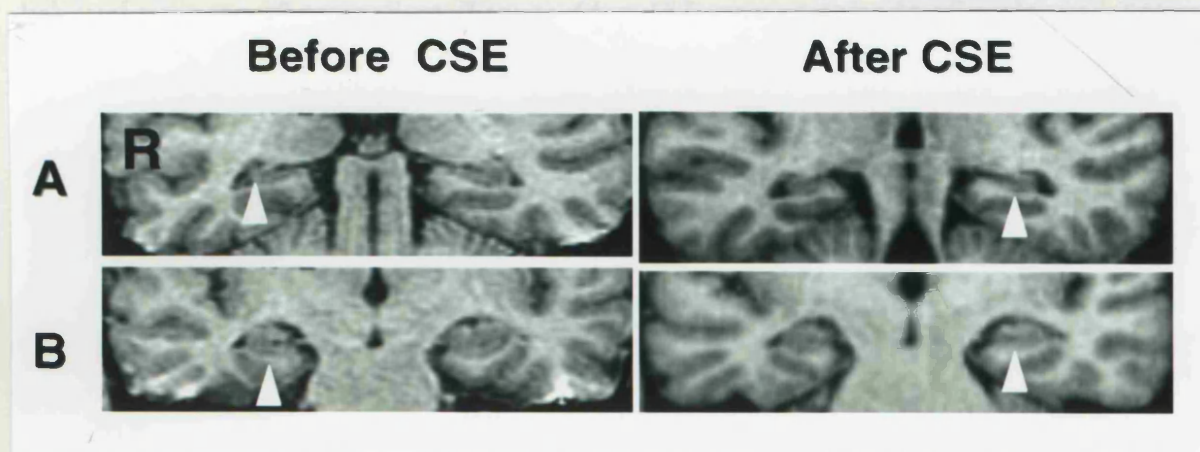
Progression from unilateral to bilateral HS. The patient was a 46 year old right handed man whose birth and early development were normal. The onset of habitual epilepsy was at the age of 4 years. There was no history of meningitis or FCs. The first seizure was an episode of CSE with left sided predominance, left sided Todd's paresis and right sided EEG focus. At the age of 12, he had 4 SGS with left sided predominance and no recovery of consciousness between seizures. He had a left Todd's paresis which resolved over one day. He had on average 4 SGS a year and was seizure free for 9 years from the age of 28 to 37 years. At the age of 35, he developed CPS with no aura, characterized by a vocalization, followed by staring, smacking movements of the mouth and swallowing, and dystonic posturing of the left arm with occasional SGS. The seizures continued at a frequency of 2 to 3 per year. At the age of 46 years, MRI of the brain (GE Signa 1.5 T, SPGR volume acquisition) showed right hippocampal atrophy without signal abnormality (white arrows in "before CSE"). Right HCV was 2877 mm^3 which was 5 SD below mean control values ($5180 \pm 416 \text{ mm}^3$) and the left HCV was 4095 mm^3 , which was 2 SD below mean control values. The HCVR (R/L) was 0.70. Several interictal EEGs consistently showed right sided temporal delta activity without epileptiform activity. One month after the MRI, he had an episode of CSE, characterized by 9 serial SGS over 12 hours with no recovery of consciousness between seizures. Four months later, he had another episode of CSE with 5 serial SGS and without recovery of consciousness between seizures. After this episode of CSE, he complained of severe memory difficulties. An MRI was repeated 4 months after the last episode of CSE (Siemens SP63 Magnetom, 1.5 T, MPRAGE volume acquisition) and showed bilateral and symmetric hippocampal atrophy. Right HCV was 2951 mm^3 and comparable to the previous measurement, but the left HCV had decreased by 25% to 2998 mm^3 (white arrows in "after CSE"). HCT2s were 106 msec bilaterally and within normal limits ($NI \leq 108 \text{ msec}$). [Hospital number: MVP12799].
